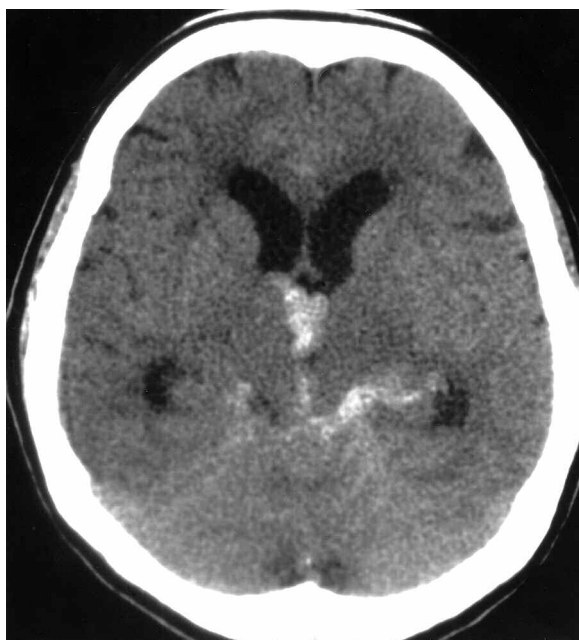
Non-contrast CT scan of the head shows subarachnoid haemorrhage in the ambient and quadrigeminal cistern, associated with intraventricular haemorrhage in 3rd ventricle.
